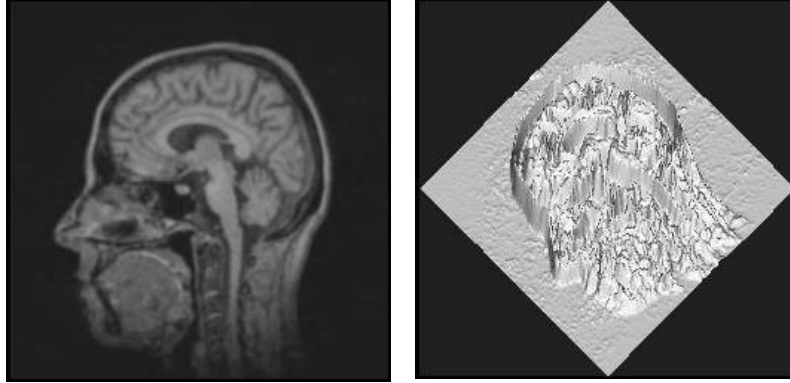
a. An MRI Slice, and b. Associated 2D intensity map in 3D (Figures are reproduced from [32])
